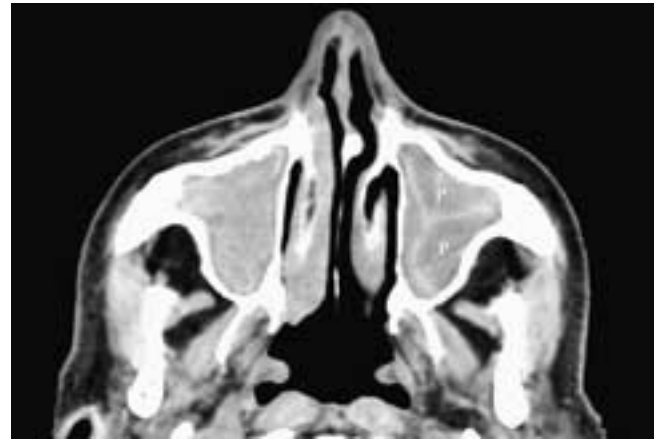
Axial CT scan shows both maxillary sinuses to be filled. On the right side, there is higher-attenuation material centrally within the sinus cavity representing desiccated secretions. However, on the left side, desiccated secretions form a thin curvilinear zone of higher attenuation, outlining the mucosal polyps (P) in this sinus.
